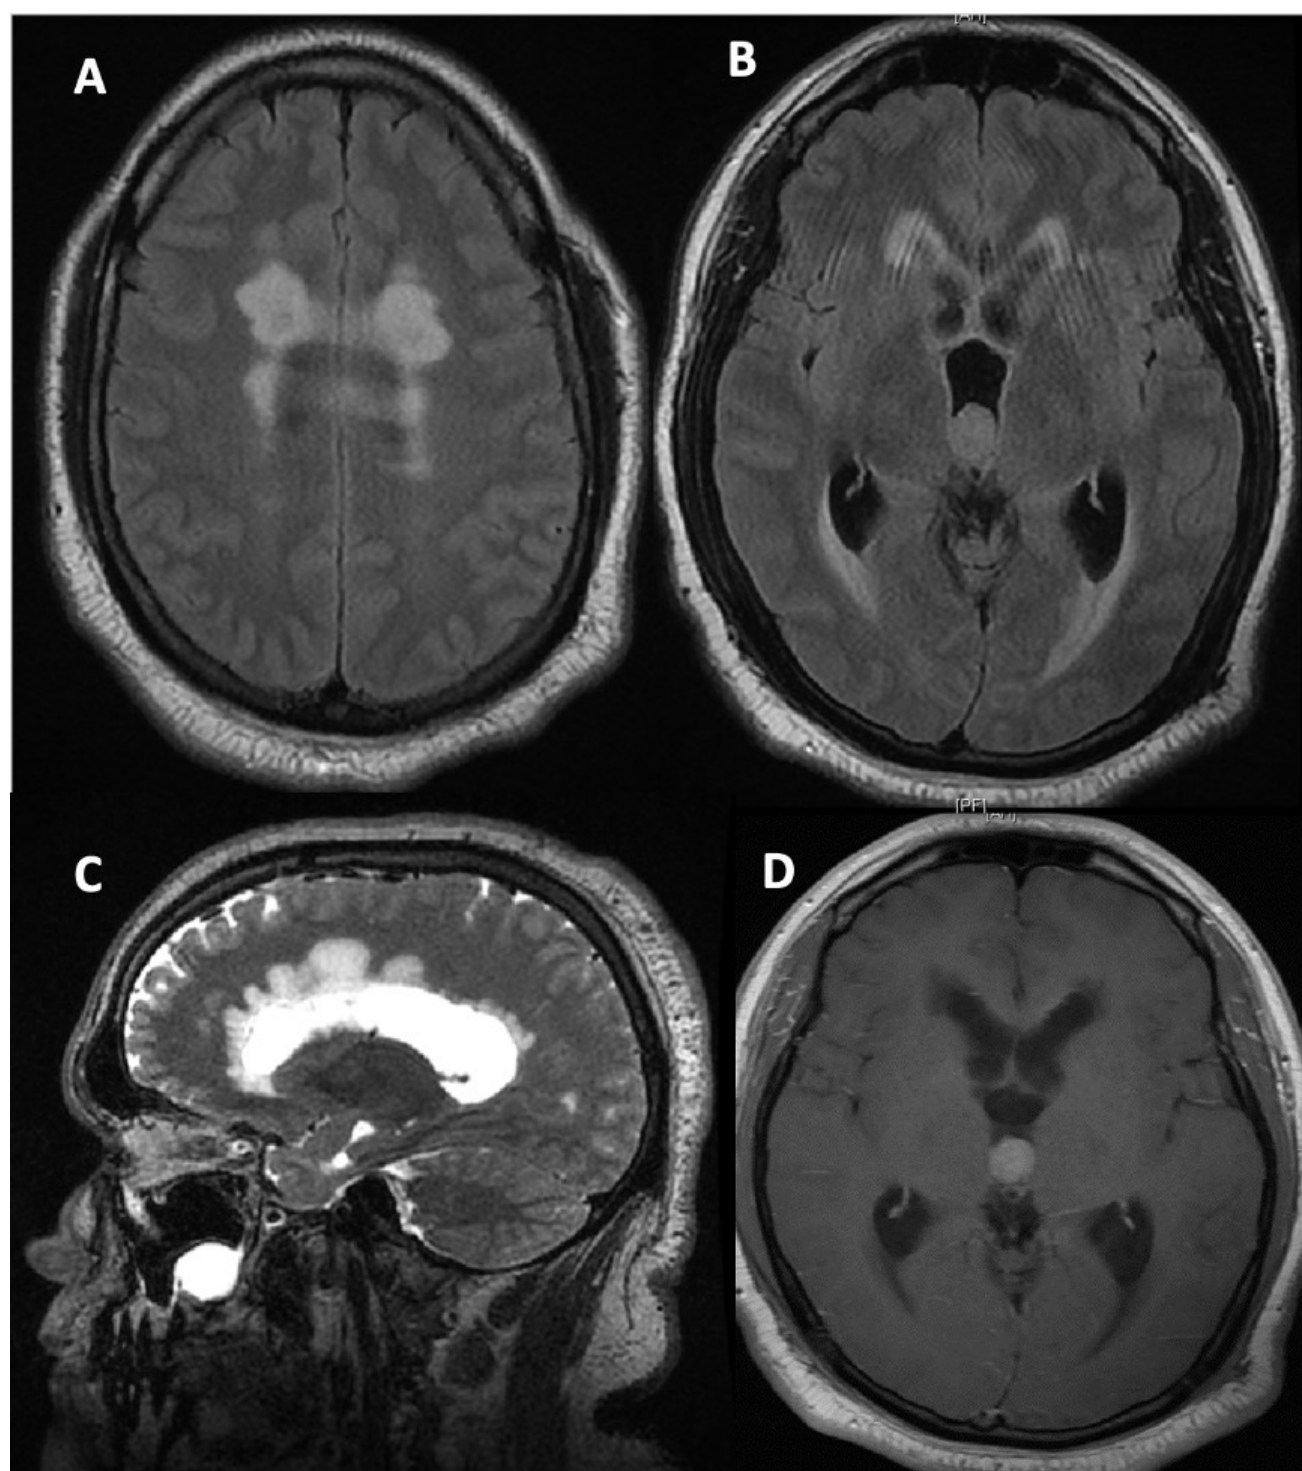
Subsequent MRI showing worsening lesions, ovoid 3rd ventricular mass, & obstructive hydrocephalus
